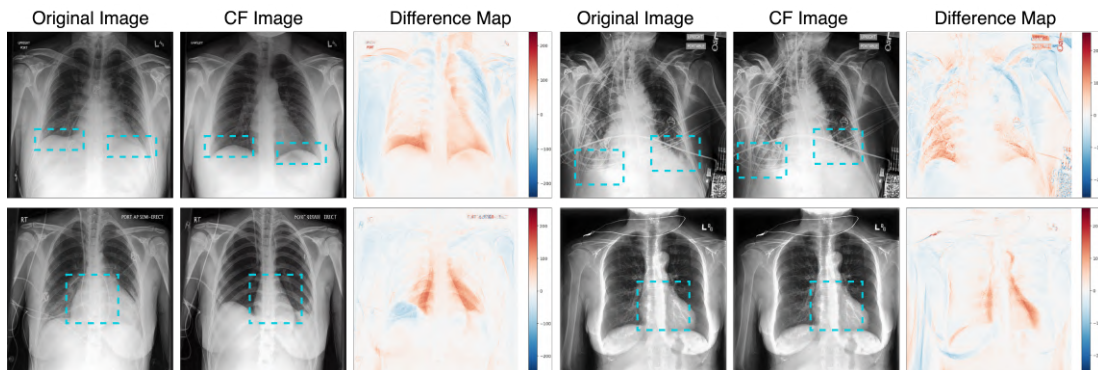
Sample pairs of original and edited images showcasing accurate, precise and high-resolution generated CFs for [disease pathology](#) explainability. The original (T) and edited text prompts (T') are - Row 1: T - chest x-ray of the patient with severe pleural effusion, T' - chest x-ray of the patient with no finding; Row 2: T - chest x-ray of the patient with severe cardiomegaly, T' - chest x-ray of the patient with no finding.
